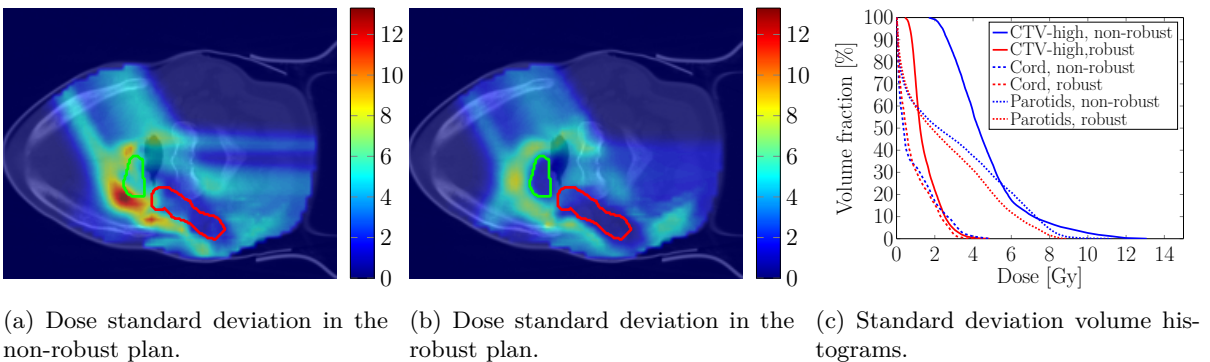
The standard deviation of the dose (in Gy) on a CT slice in the middle of the CTV (highlighted in green and red) and standard deviation volume histograms of the example HN patient.
